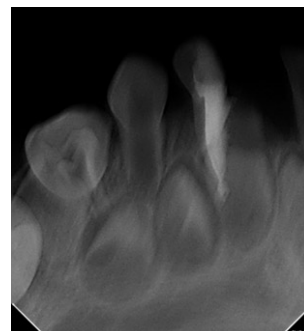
Periapical radiograph after filling of calcium hydroxide paste.
